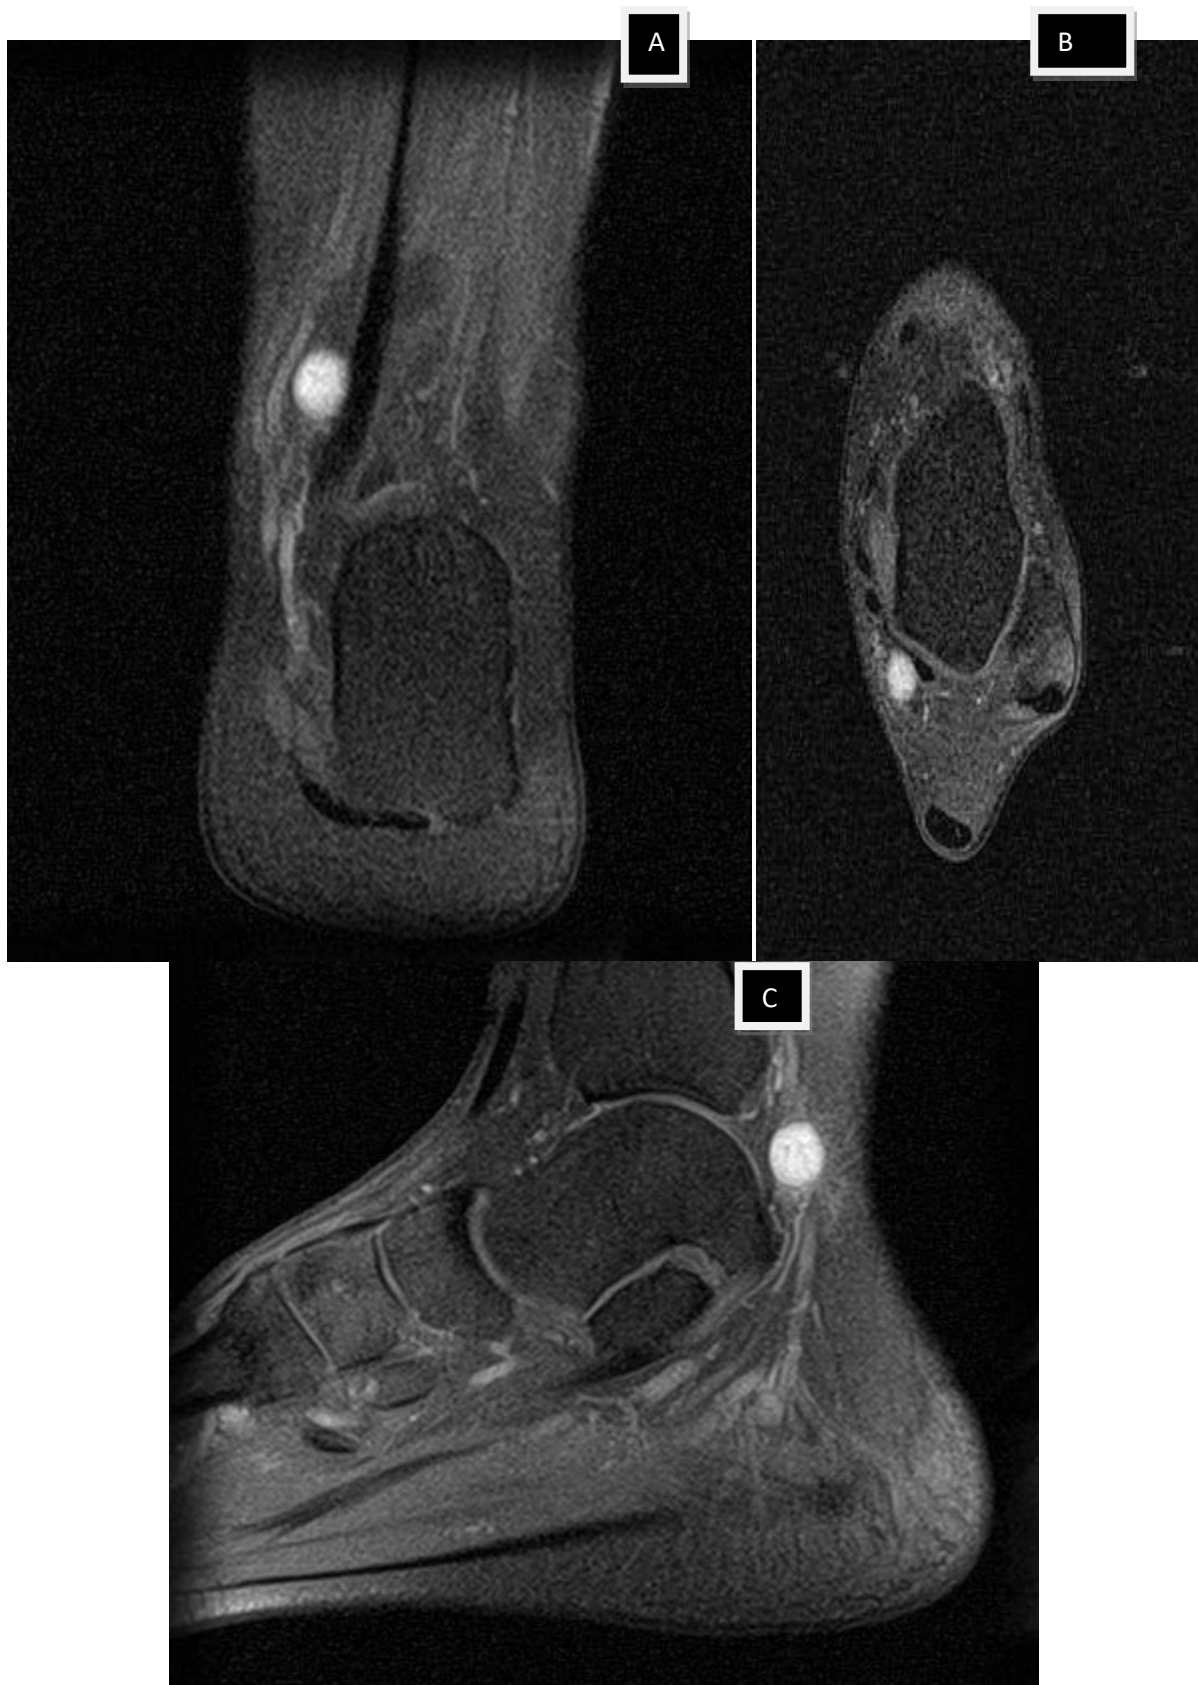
(a) Coronal MRI showing enhancement of lesion with contrast adhering to posterior tibial nerve (b) Axial MRI cuts showing enhancement of lesion with contrast (c) Sagittal MRI cuts showing enhancement of lesion with contrast adhering to flexor hallucis tendon
